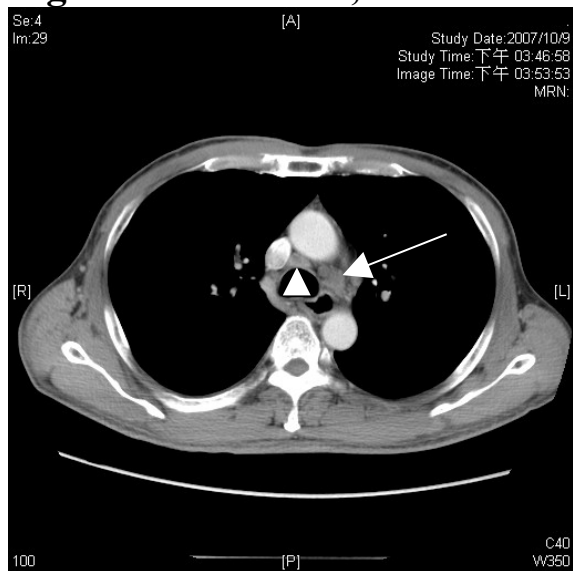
Panel B. Chest CT, Pre-OP:
